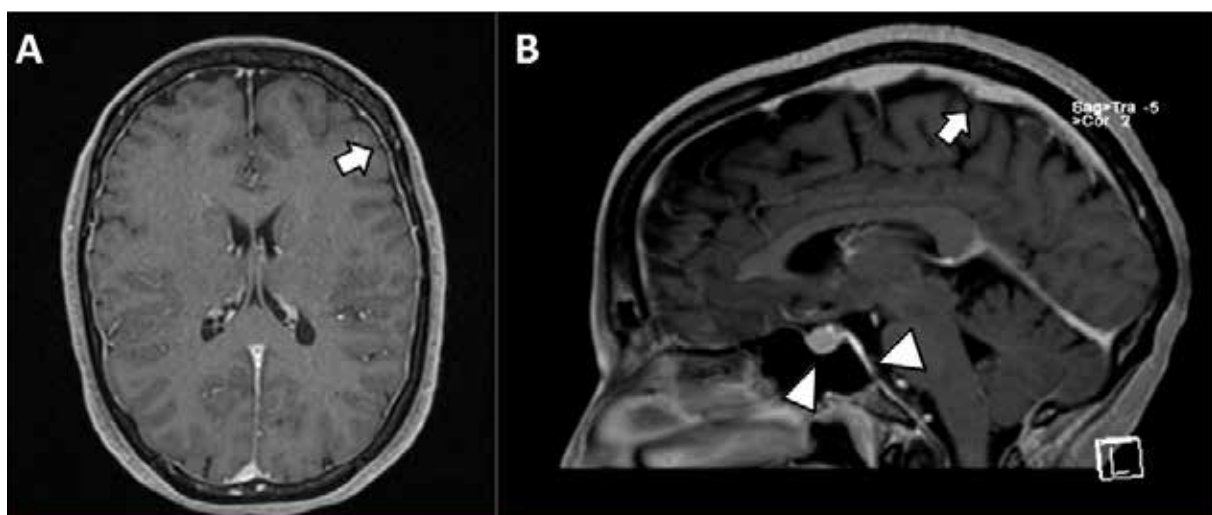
A, B) MRI T1 C+ shows slight diffuse meningeal thickening with contrast enhancement (arrows). Sagittal reconstruction demonstrates slight thickening of the clivus and pituitary gland (arrowheads).
